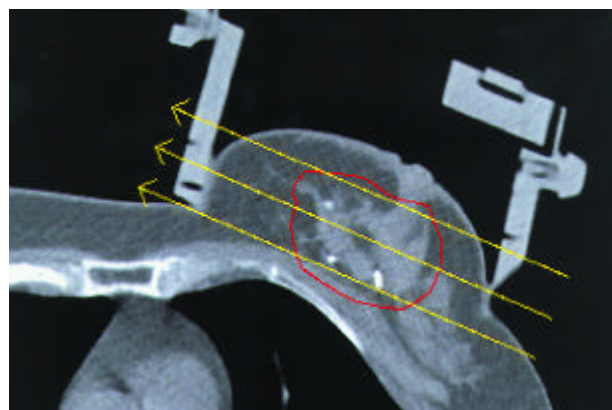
3D virtual brachytherapy – preimplant CT-scan with template on the breast. Three titanium clips mark the boundaries of the excision cavity. Target volume is delineated (red); preplanned position of implant needles in three planes (yellow arrows).
